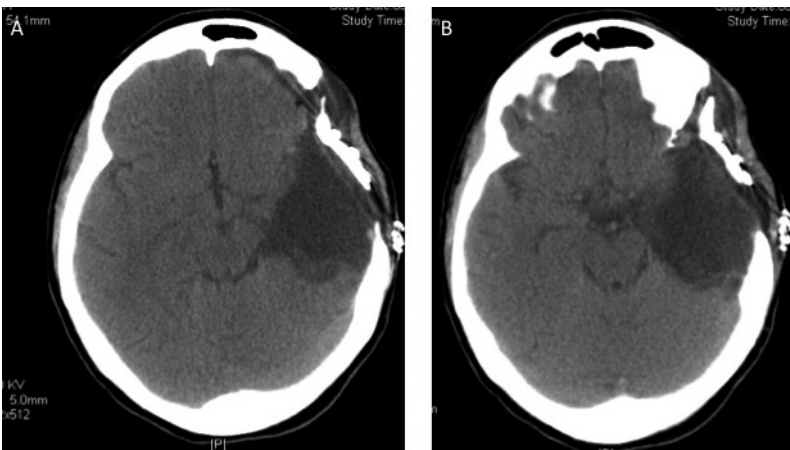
A, B) Control CT scan after the third operation.
